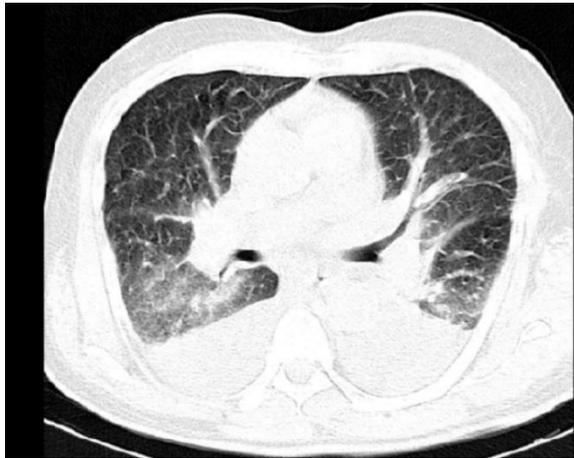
Typical basilar ground glass pattern in both lungs in high resolution computed tomography indicated to COVID-19
